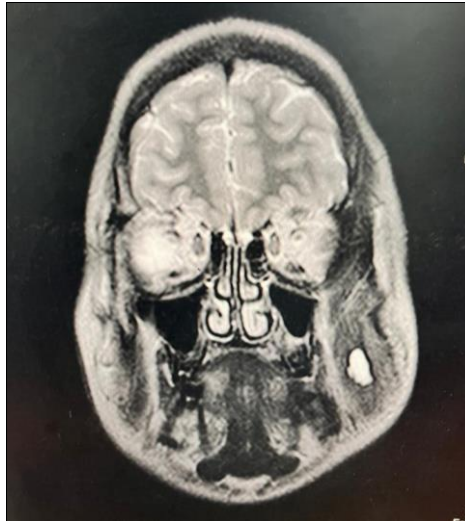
MRI Head and Neck: T2 hyperdense intramuscular cystic lesion involving masseter muscle, oval shaped showing smooth margins and no obvious internal solid component? Myocysticercosis.
